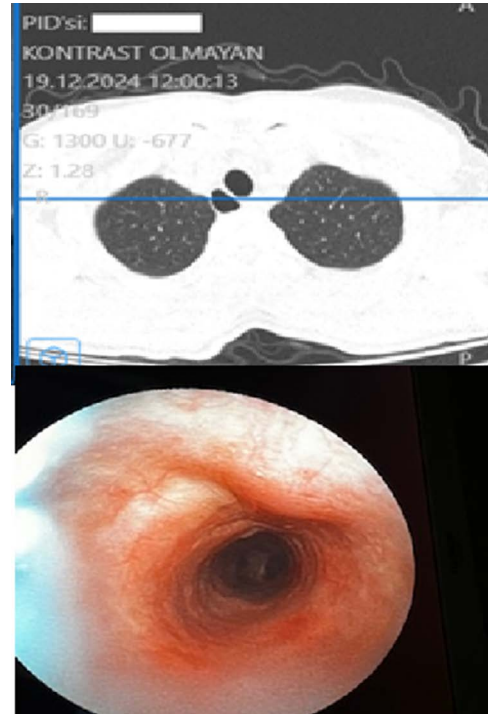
Axial thoracic computed tomography image demonstrating a tracheal diverticulum and bronchoscopic view showing bulging of the posterior tracheal wall (Case 3).
